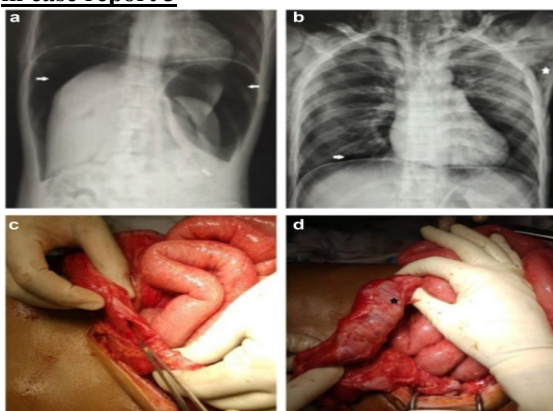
X-ray picture showing pneumoperitoneum 3c, 3d.: colonic perforation of 3 cms size seen during emergency laprotomy in case report 3
